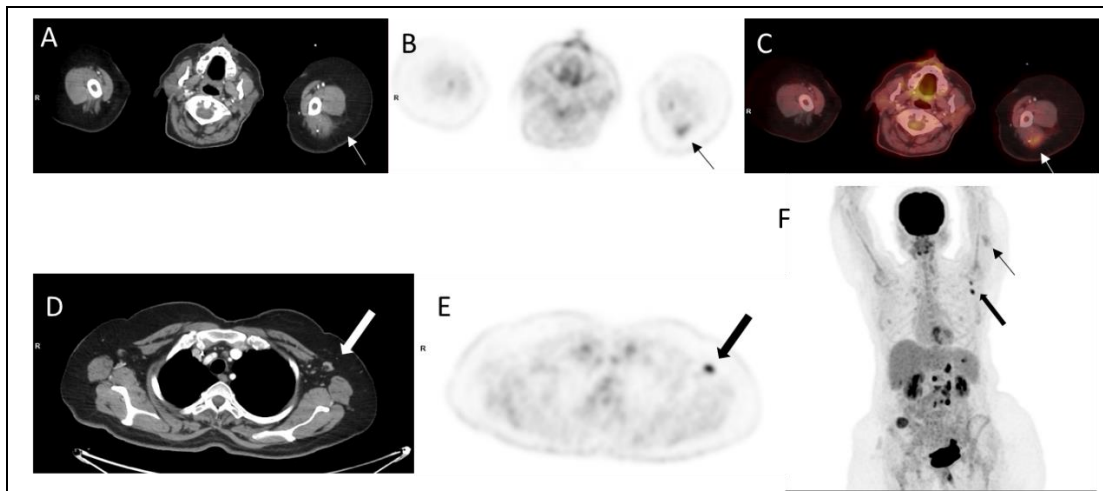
52-year-old female with gastro-intestinal tumor was referred for routine F18 FDG PET/CT follow up study. The study was performed two days after the second COVID19 vaccination. Selected transaxial CT (A, D), and PET (B, E) slices at the level of posterior arm uptake and axillary lymph nodes , fused image (C) at the level of posterior arm uptake and MIP (F) demonstrate moderate intensity uptake in the left posterior arm, SUV max 3.6 (thin black and white arrows) and high grade activity in left axillary nodes measuring 1.0 cm in short axis with benign appearances (thick white and black arrows), SUV max 7.1. The MIP also shows high grade FDG activity in retroperitoneal nodes and multiple implants.
